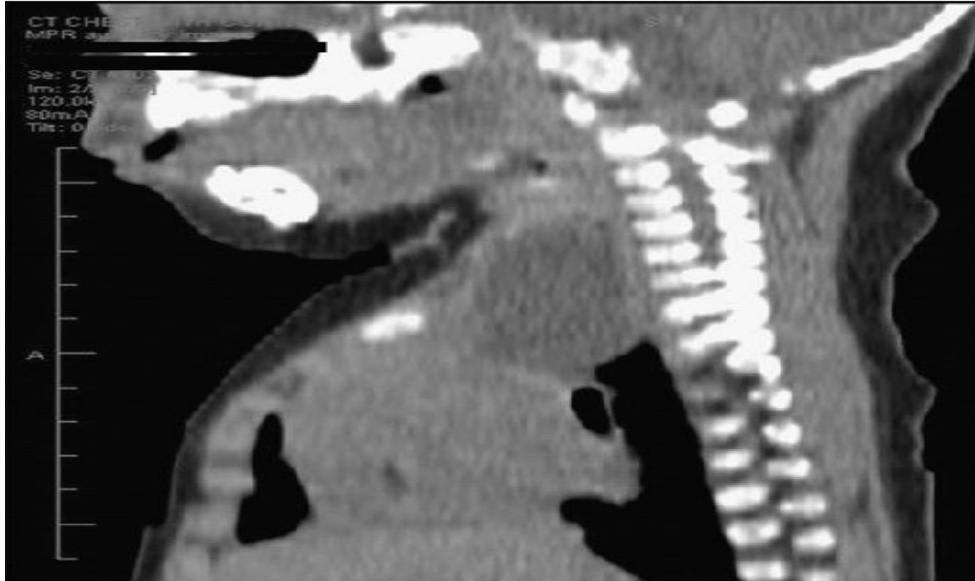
Sagittal view of the CT showed cervical duplication
